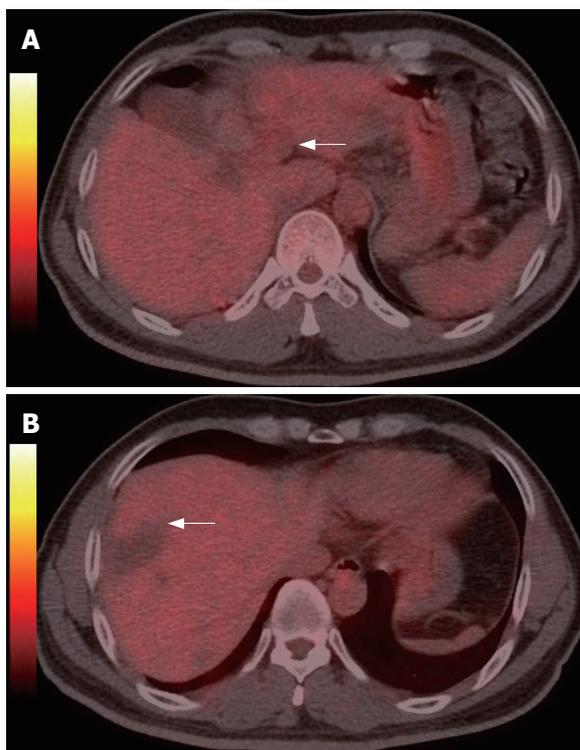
Fused PET/CT imaging showing no hypermetabolism (arrow) in the region of the left portal vein (A) and in the region of previous hepatic resection (B).
